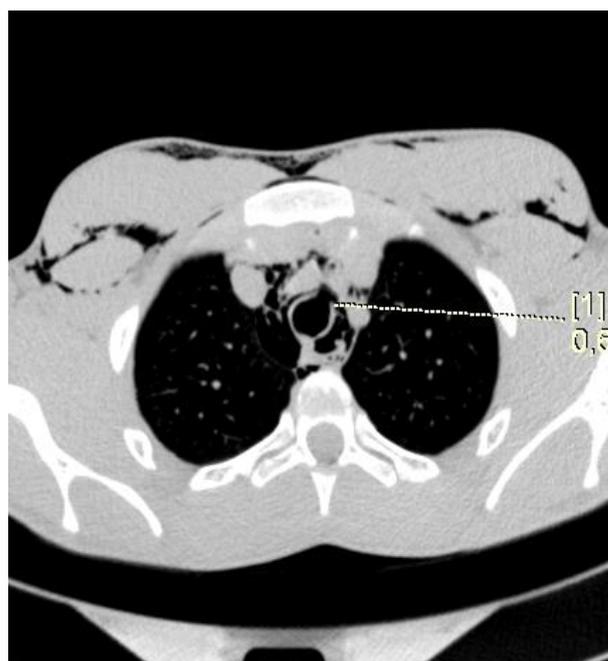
CT, axial projection, tracheal rupture, pneumomediastinum
